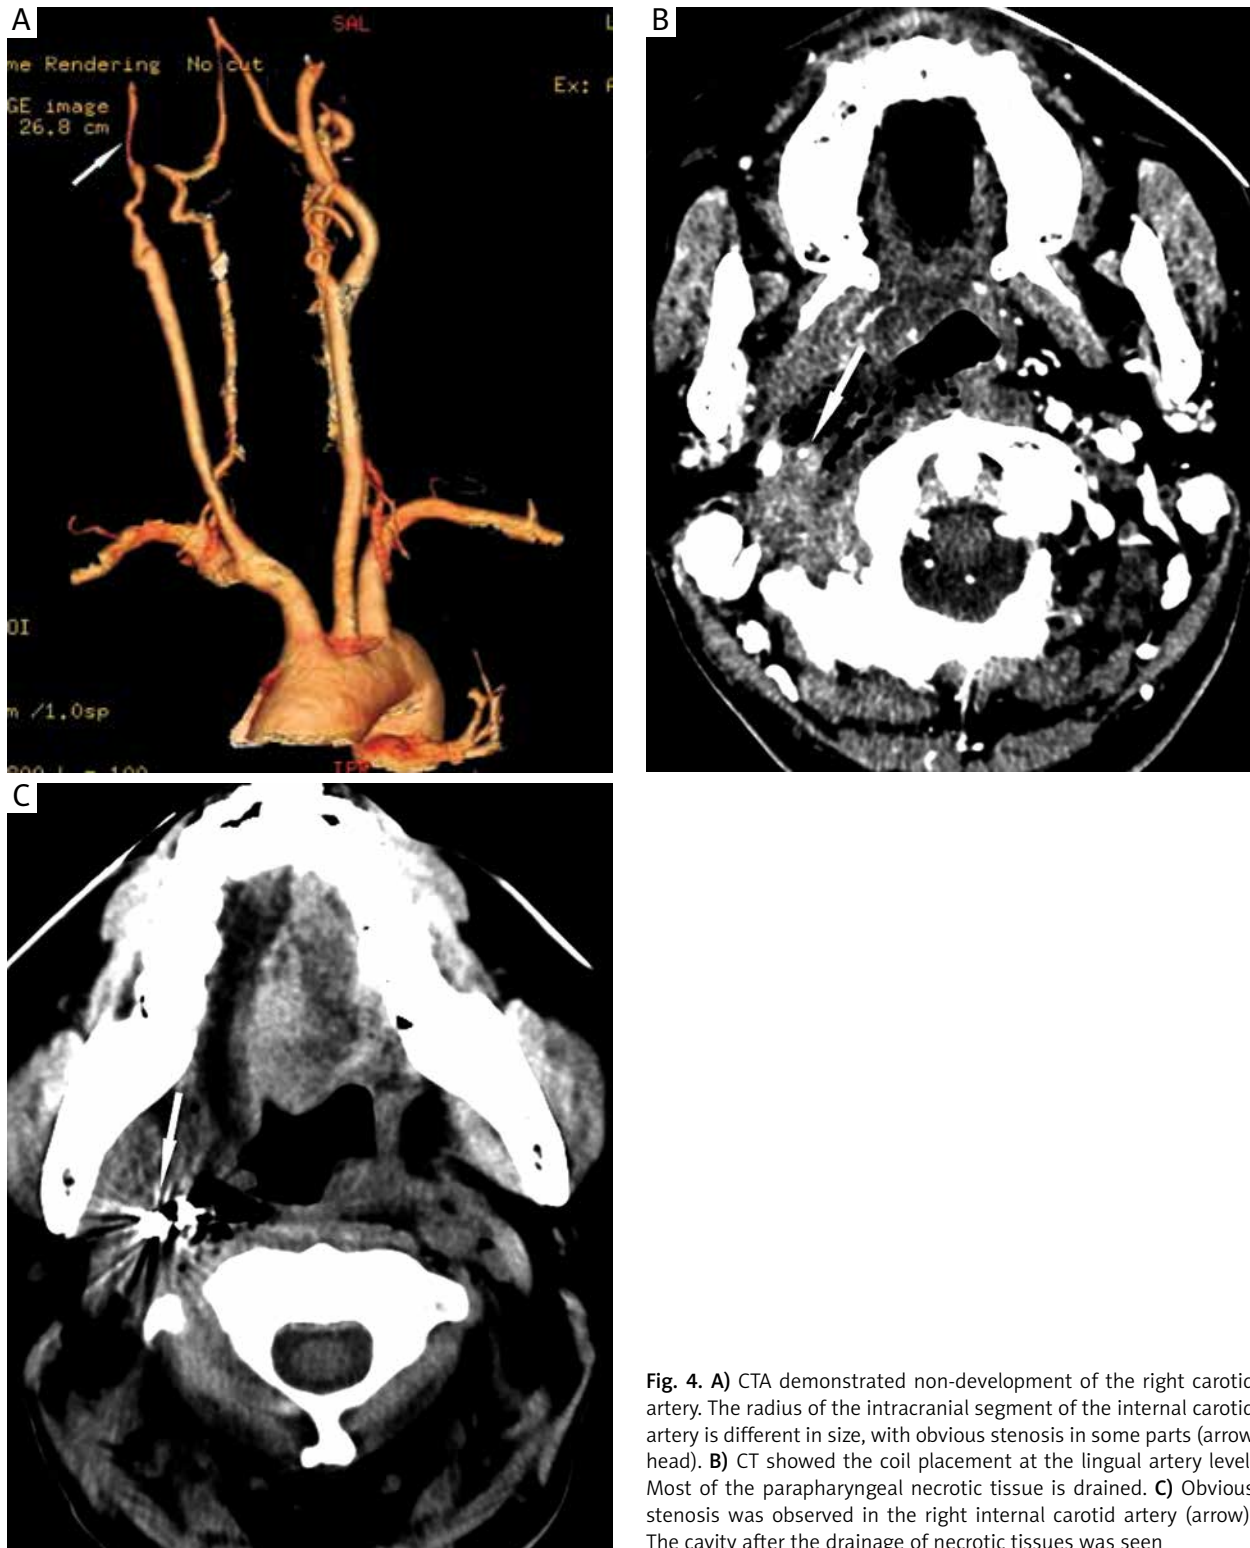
A) CTA demonstrated non-development of the right carotid artery. The radius of the intracranial segment of the internal carotid artery is different in size, with obvious stenosis in some parts (arrow head). B) CT showed the coil placement at the lingual artery level. Most of the parapharyngeal necrotic tissue is drained. C) Obvious stenosis was observed in the right internal carotid artery (arrow). The cavity after the drainage of necrotic tissues was seen
